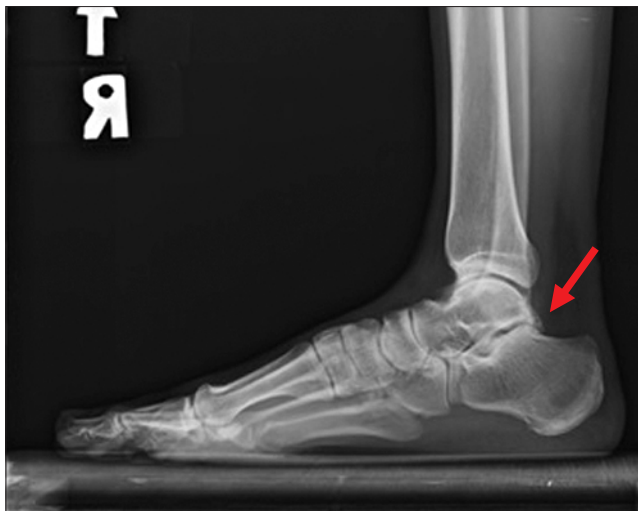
Simple lateral radiograph of ankle revealed osteophyte of posterior aspect of the talus on lateral view (arrow).
